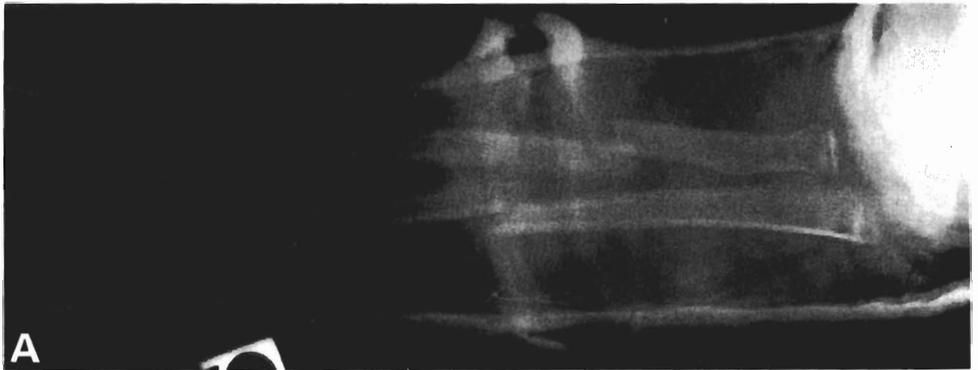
Four weeks after the fracture was originally manipulated the bones were still end-to-end but had become angulated. The fracture was manipulated again, and the radiograph taken 6 months later shows an excellent result. The range of movement was full. Boy aged 5 years. Correction of angulation when a fracture is sticky is a useful technique.
